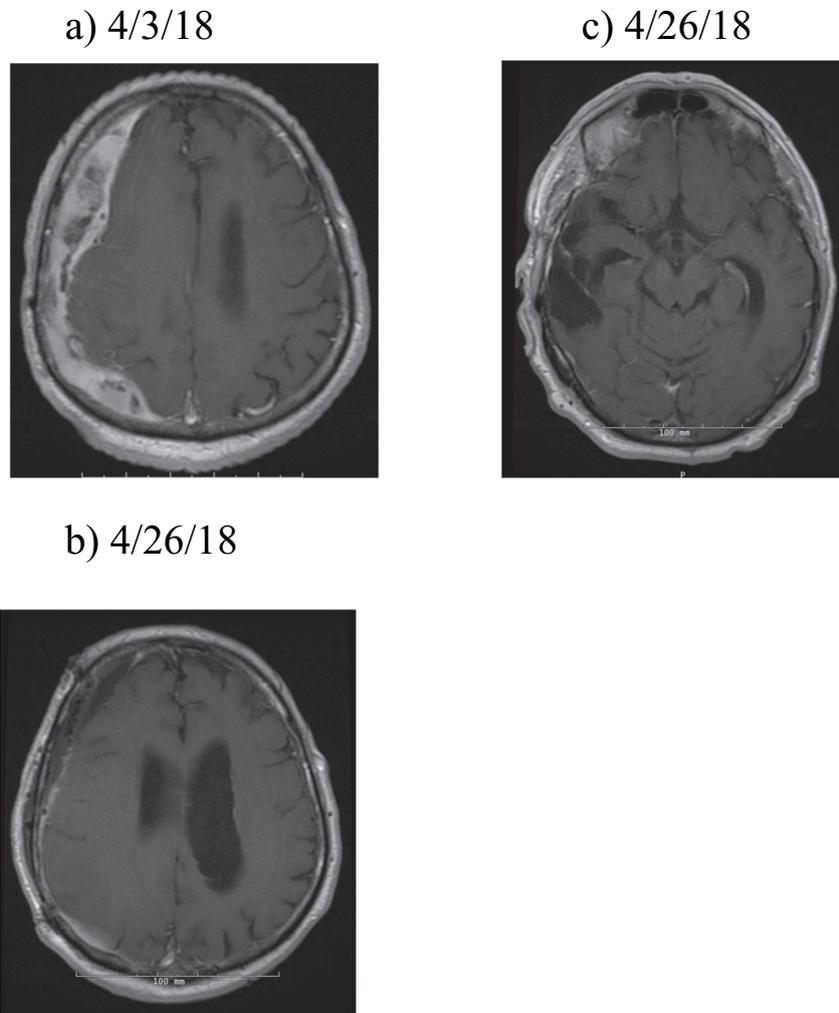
a: Axial T1 weighted MRI showing significant progression in enhancing subdural mass
